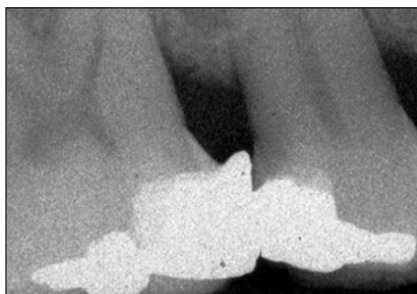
Preoperative radiographic image of tooth #14 with with mesial overhang.
